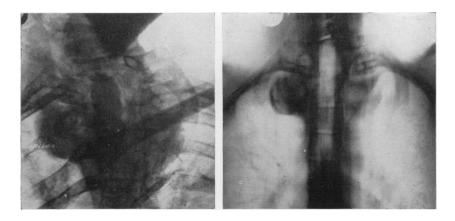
(a) and (b). Frontal radiography and tomography of a nineteen-year-old patient with paraplegia due to a chondro-sarcoma involving D.1-D.2-D.3 and extending bilaterally into the posterior thoracic area. Notice the spinal block at D.3-D.4.
